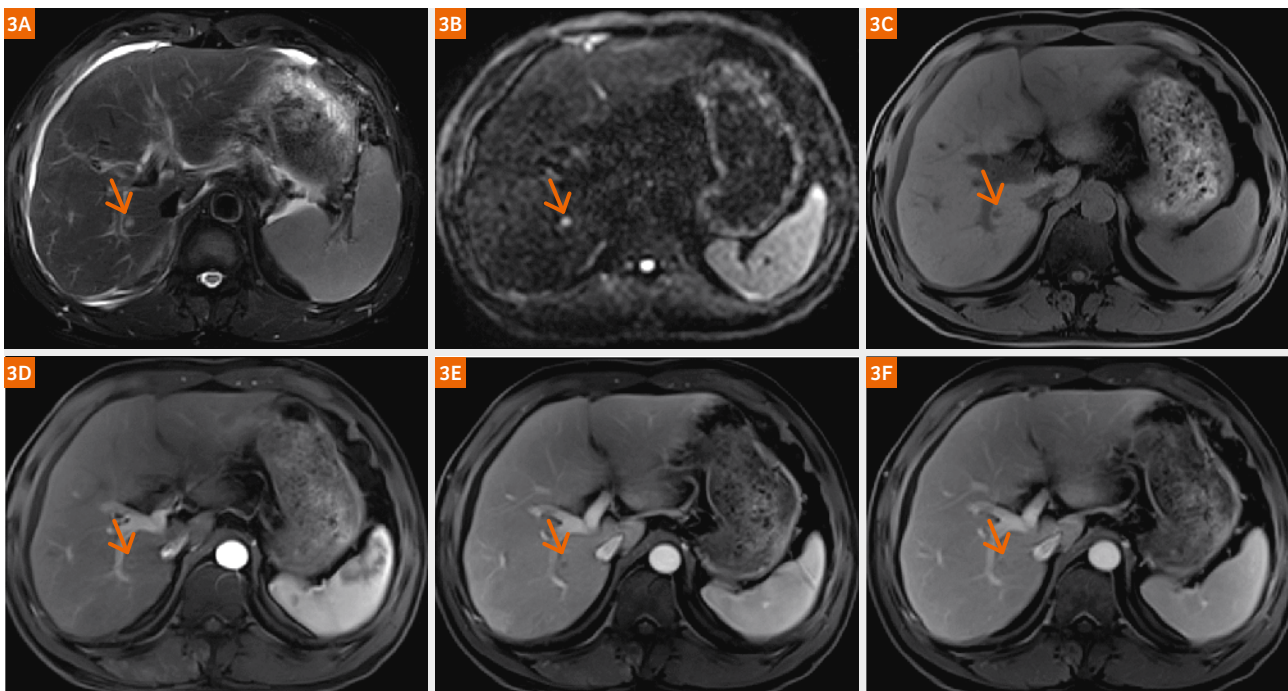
Liver metastasis (primary: colon cancer) in a 46-year-old man: (3A) T2-weighted BLADE; (3B) DWI, $b = 1000 \text{ s/mm}^2$; (3C) pre-contrast T1-weighted; (3D-F) contrast-enhanced T1-weighted. The lesion is isointense to hyperintense in T2-weighted images, is hyperintense in DWI, and has low intensity in T1-weighted images. Annular enhancement is visible in the arterial phase of the enhanced T1-weighted images relative to the surrounding liver parenchyma.
